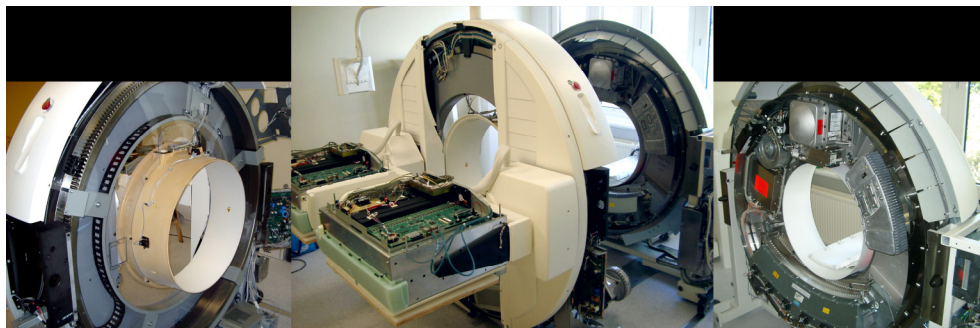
Siemens Symbia T6: Left: Gantry of the dual head gamma camera, Center: both parts separated during service, Right: Gantry of the 6 slice MD CT
